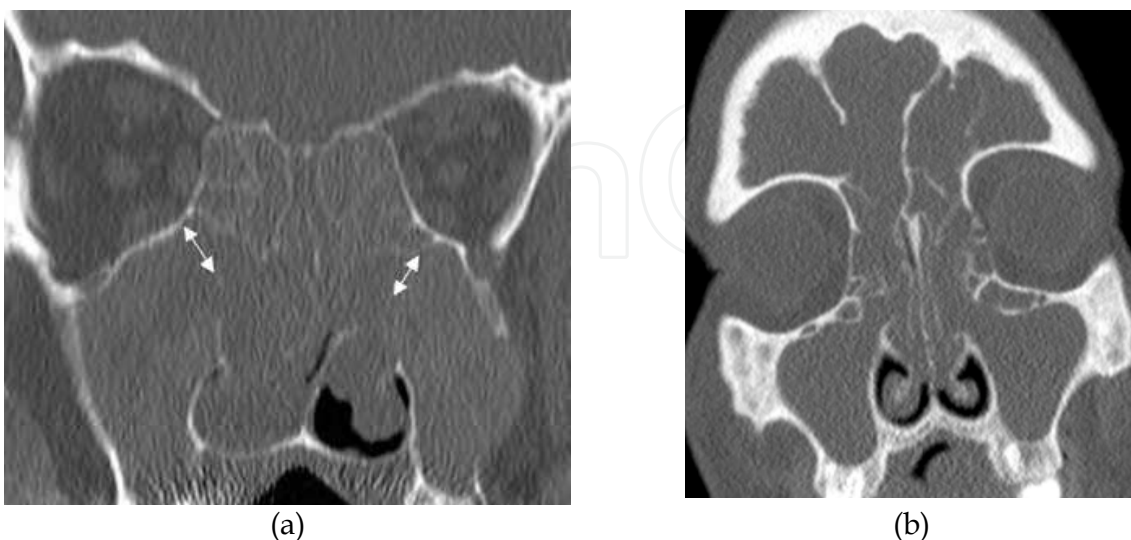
(a) Coronal CT of polyposis inflammatory pattern. Note the typical broadening of the ethmoid infundibulum bilateral (arrows). (b) Another patient where coronal CT also shows the involvement of the frontal sinuses.
